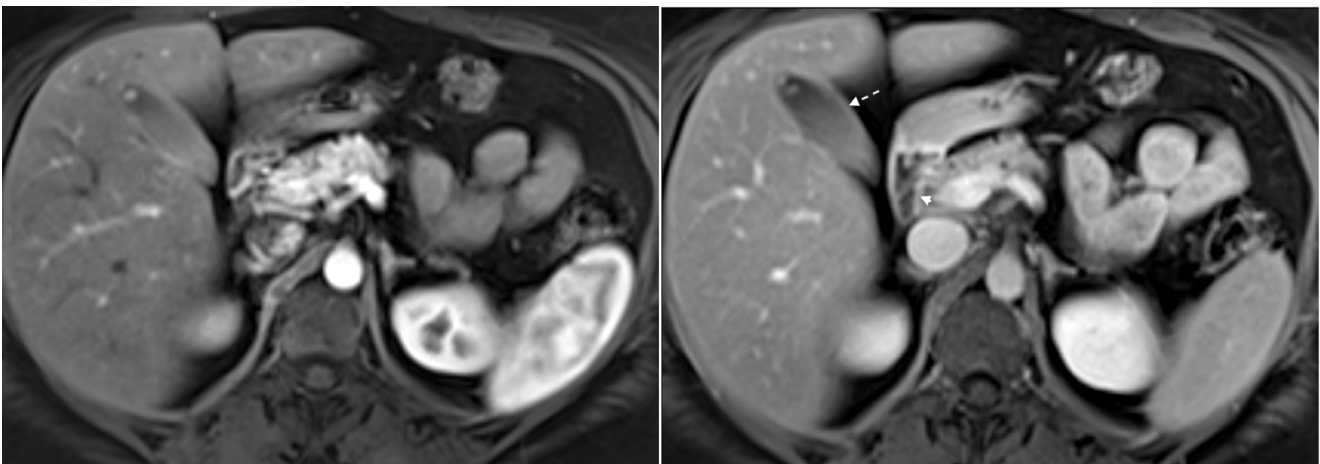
Chronic acalculous cholecystitis with simultaneous upper GI inflammation. Axial T1-weighted images acquired in the arterial phase (a) and the interstitial phase (5-minute delay) (b). Progressive increased mural enhancement of the duodenum is observed in the interstitial phase (short arrow, b). Moderately increased enhancement of the gallbladder is shown as enhancement of the gallbladder wall that shows progressively increased intensity from arterial phase to interstitial phase enhanced images (dashed arrow, b). Incidental gallbladder polyp was observed.
